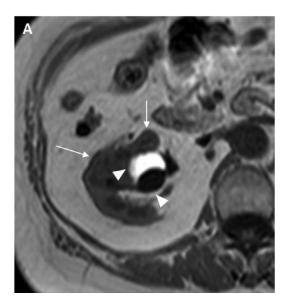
MRI of the right kidney (A: T1-weighted image, B: T2-weighted image). The solid component of the tumor shows isointensity relative to renal cortex on T1-weighted imaging and low signal intensity on T2-weighted imaging (arrows). The mass contains multiple cystic structures that contain both hypointense and hyperintense components (arrowheads).
